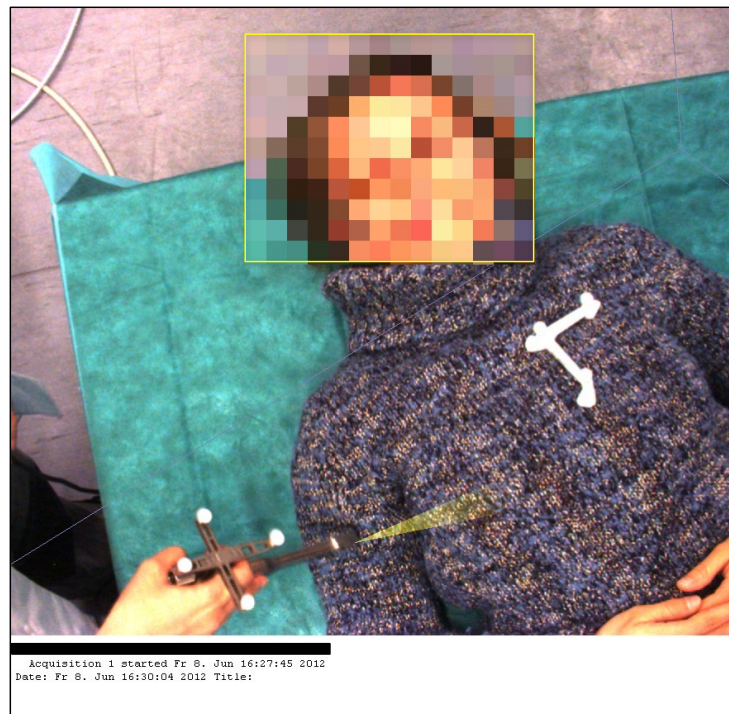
Exemplary Freehand SPECT screenshot of a test scan. The face of the person was clearly visible and therefore is blurred using the tool as shown here (yellow rectangle). The white box on the bottom of the screenshot includes information embedded into the image, the name and birthdate of the patient is always shown in the first line and needs to be removed if necessary (blackened).
